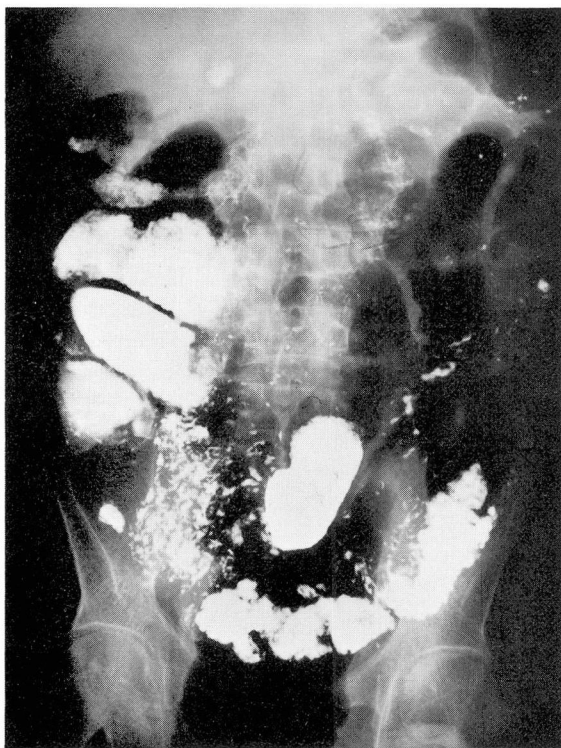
Case 1. Roentgenogram of the small bowel, showing dilatation of the bowel, and flocculation and segmentation of the barium mixture.
